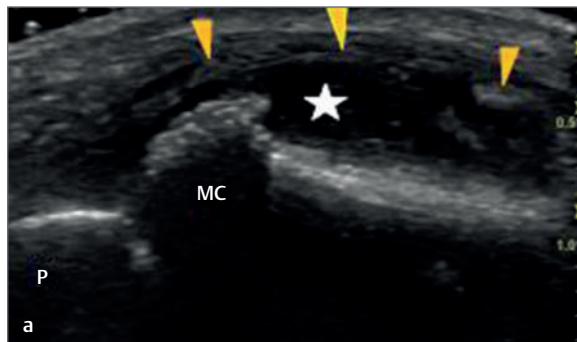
(a) Longitudinal image of the metacarpophalangeal joint of the thumb. The head of the metacarpal (MC) appears prominent in relation to the phalanx (P) indicative of subluxation. In addition, there appears to be a significant effusion (white star) and synovial thickening (yellow arrowheads). The patient had a chronic and active rheumatoid arthritis. (b) This is the same image as in part (a), except Power Doppler imaging has been used to demonstrate that the thickened synovium is actively inflamed.
